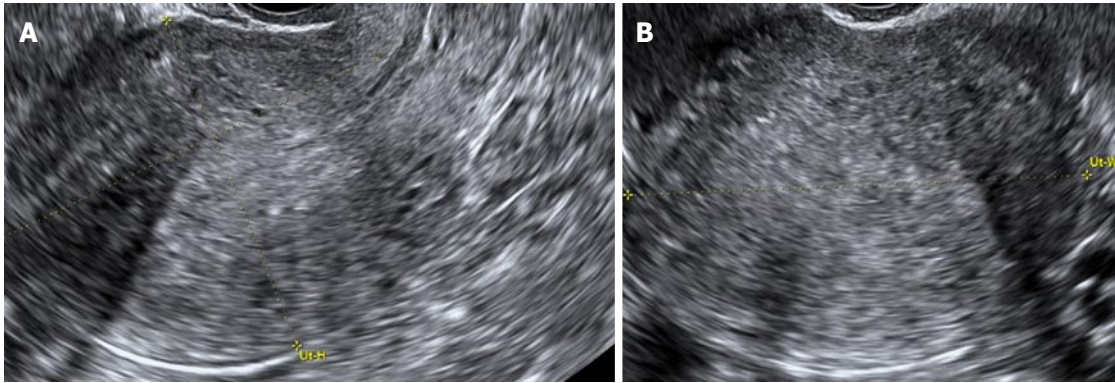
Adenomyosis with loss of the endometrial-myometrial junction. Sagittal (A) and transverse (B) 2D ultrasound images show the classic "venetian blind" shadowing of diffuse adenomyosis with loss of the endometrial-myometrial junction; B: 3D coronal ultrasound image (with VCI) showing the irregular endometrial-myometrial junction. Note the left lateral intramural fibroid. 3D: Three-dimensional; 2D: Two-dimensional; VCI: Volume contrast imaging.
